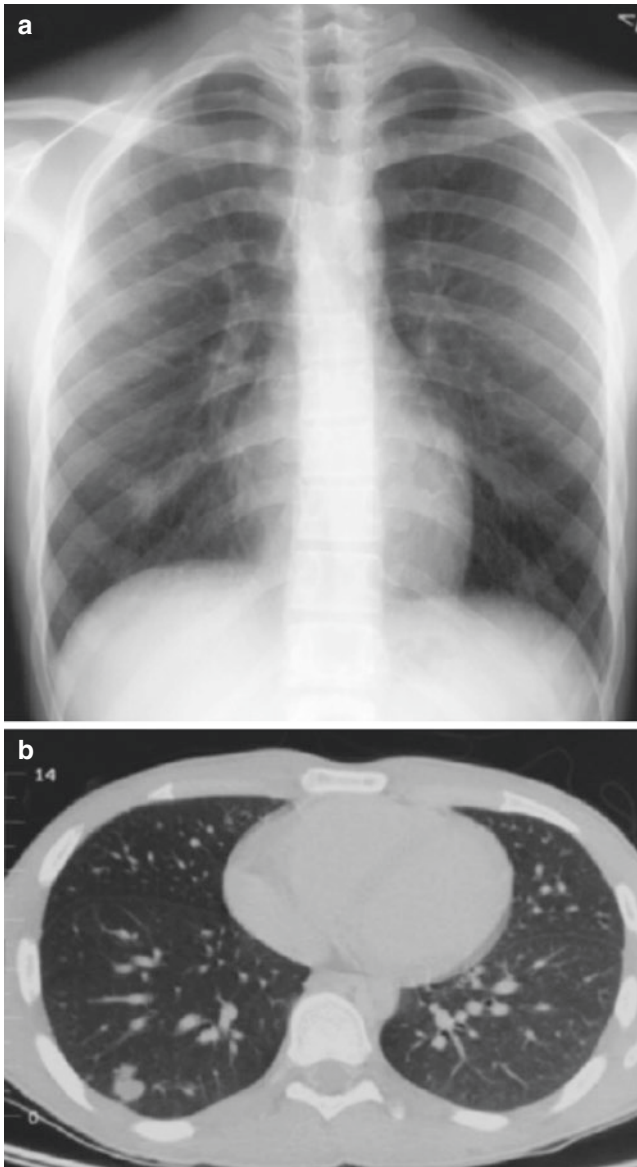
A 16-year-old girl with a history of treated neuroblastoma who presented with right chest pain. (a) Chest radiograph and (b) axial lung window CT image show multiple bilateral pulmonary nodules, with the largest seen in the right lower lobe. Open biopsy of the right lower lobe nodule demonstrated histoplasmosis
